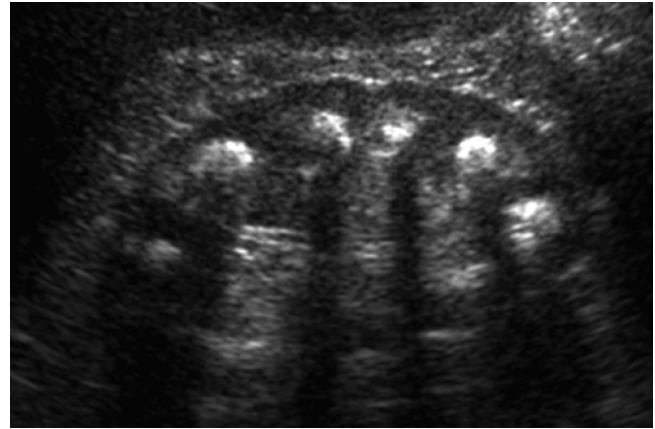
Ultrasound (US) demonstrating extensive medullary calcifications, manifesting with focal hyperechogenicity with posterior acoustic shadowing, in a patient with medullary sponge kidney
